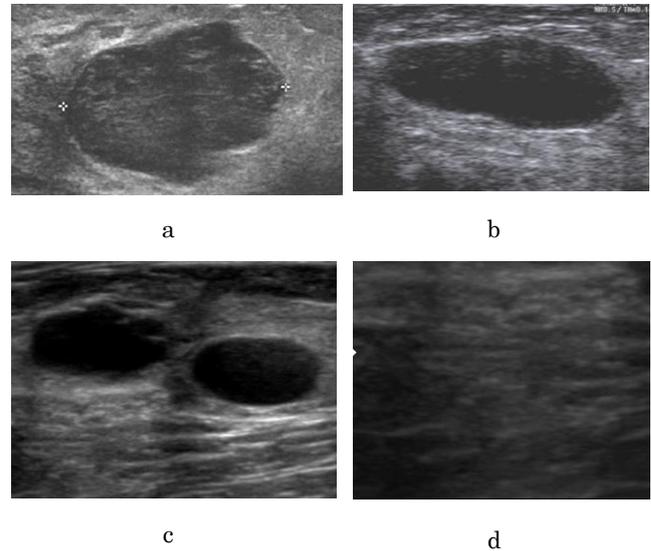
Sonograms: a – breast fibroadenoma; b – large cyst of the breast; c – multiple breast cysts and d – the breast tissue example after 3 months after surgical laser removal of benign fibroadenoma and cysts
